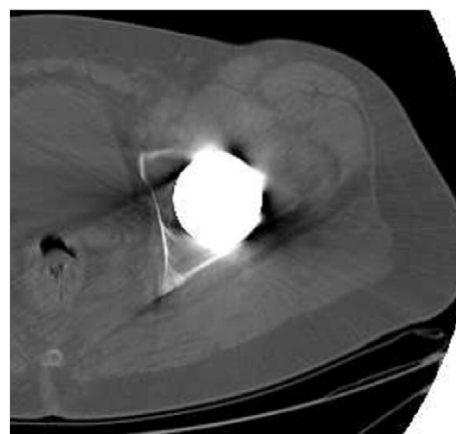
Axial computed tomographic scan image showing acetabular osteolysis and confirming acceptable component anteversion.
